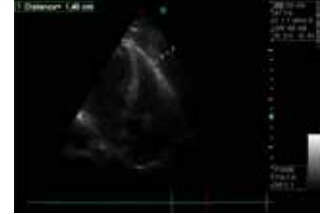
Transthoracic echocardiogram shows pericardial effusion due to the rupture of ascending aorta.
